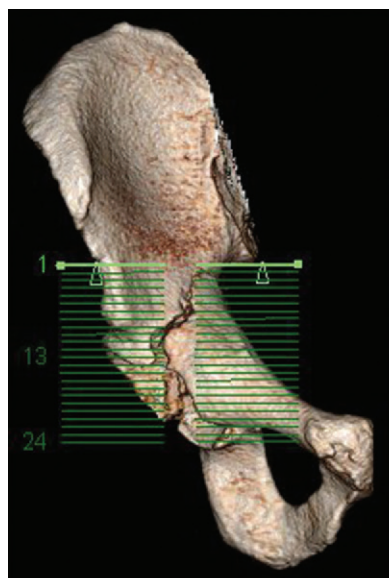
Anatomic and acetabular positioning of the hemipelvis. (a, b) Frontal (a) and lateral (b) 3D surface-rendered CT images show the acetabulum in anatomic position. The overlay grid shows how images obtained in the axial plane make the transverse fracture appear sagittally oriented. (c, d) Frontal (c) and lateral (d) 3D surface-rendered CT images show the acetabulum, which is positioned such that on the lateral view, the acetabular cup is viewed en face with the acetabular notch directed inferiorly. In this position, the transverse fracture is oriented more closely to the horizontal lines of the overlay grid.
